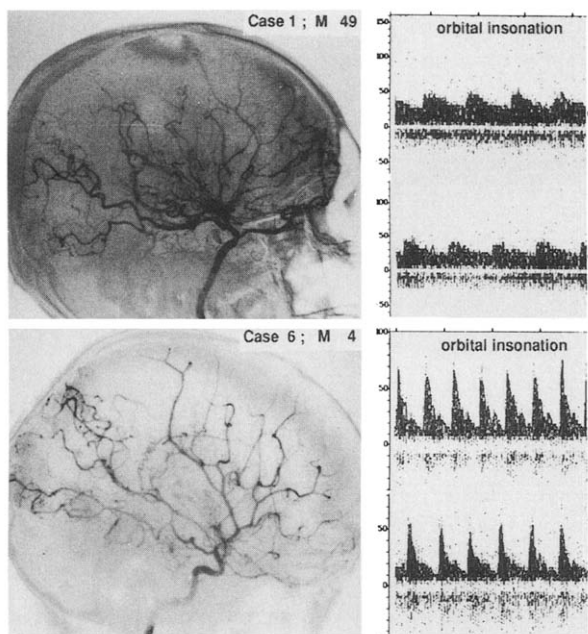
Upper pictures represented angiographic opacification and doppler signals of ophthalmic artery in adult Moyamoya cases. Lower pictures were those of children. The doppler flow pattern of the ophthalmic artery in the adult was similar to that of the intracranial vessels (relatively high diastolic flow velocity), whereas children showed patterns similar to that of the extracranial vessels (very low diastolic flow velocity).
